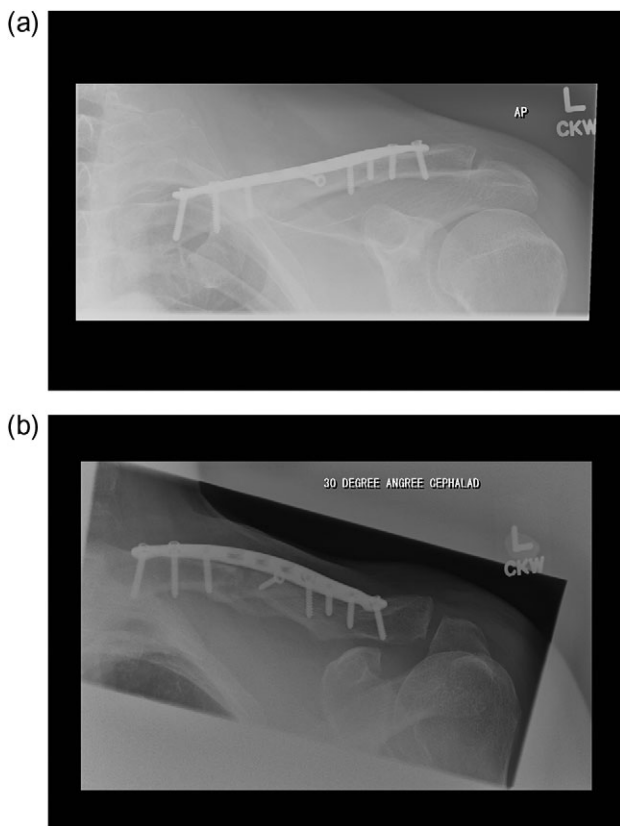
(a and b) Post-operative fixation radiographs.
